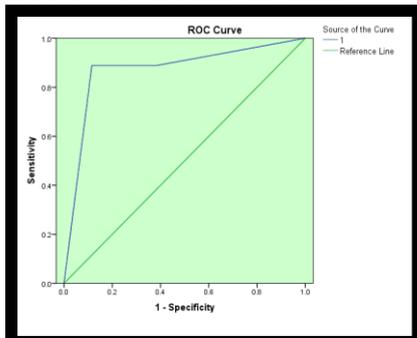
Receiver operator characteristic ROC plot: Bitewing radiograph at enamel threshold for occlusal surfaces
